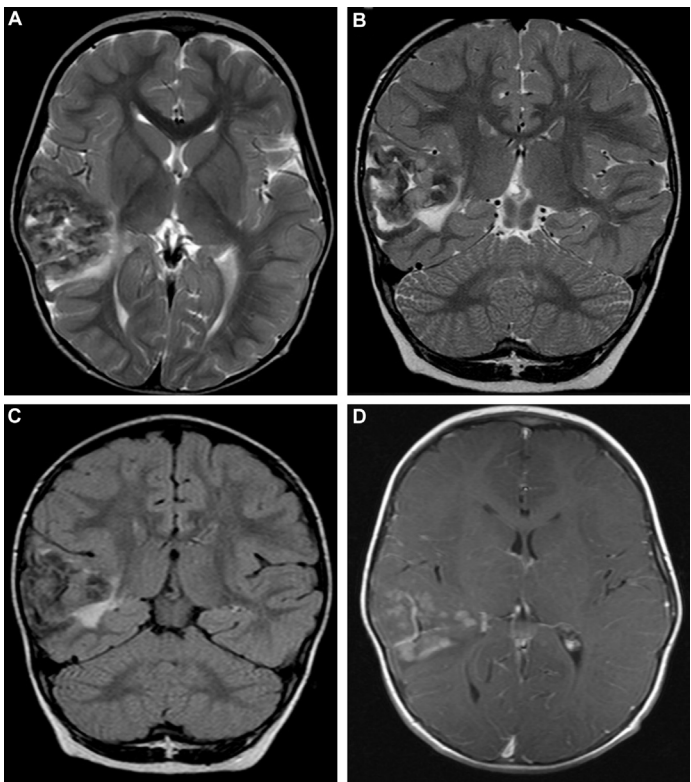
Meningioangiomas in a 3-year-old patient. (A) Axial and (B) coronal T2WI show thickened dysmorphic right temporal lobe cortex with hypointense T2 signal caused by calcification. (C) Coronal FLAIR shows the adjacent white matter edema. (D) Axial postcontrast T1WI showing heterogeneous enhancement in the meningoangiomas.
